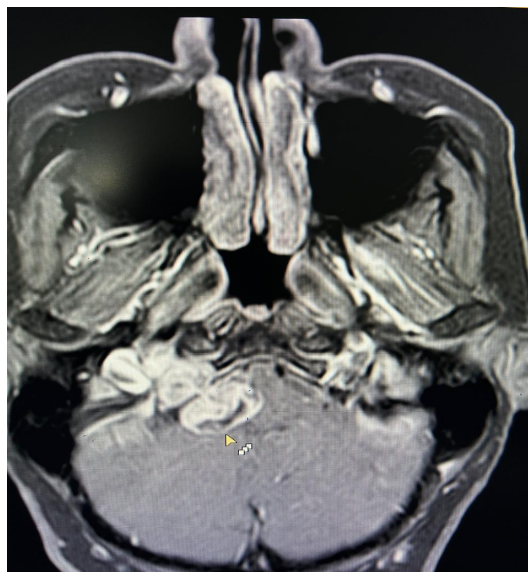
Contrast-enhanced axial T1-weighted MRI demonstrating an avidly enhancing right cerebellopontine angle mass with extension into the internal auditory canal, consistent with a vestibular schwannoma.
